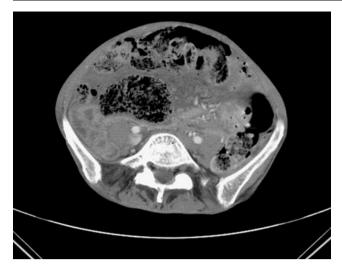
Computed tomography of the abdomen and pelvis shows colonic distention, fecal matter, and mesenteric edema.
